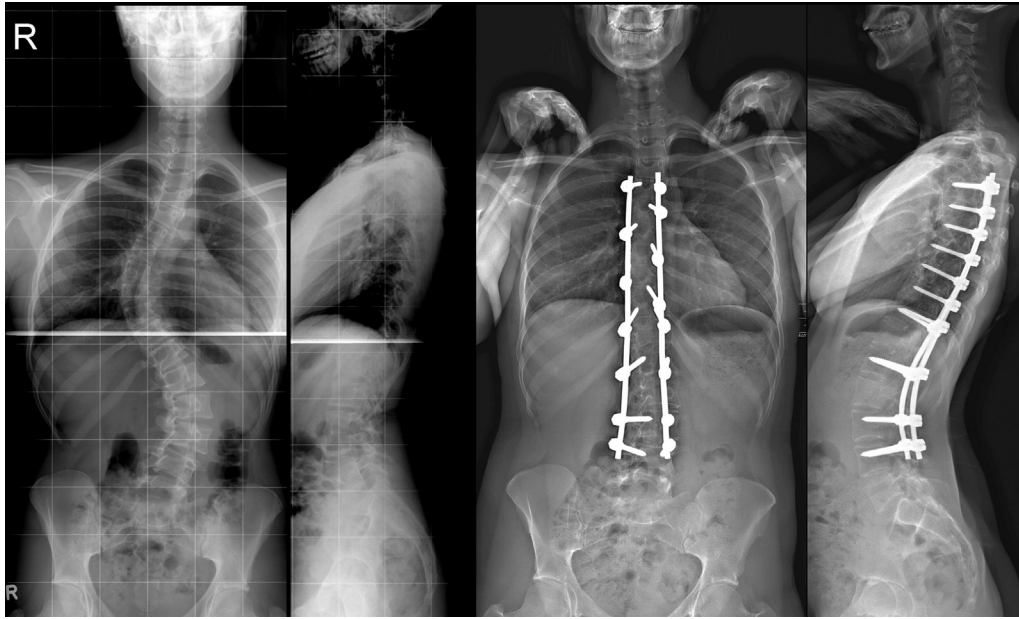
Pre- and postoperative radiographs in posterior instrumentation with correction from 60° Cobb angle to 12° in lower curve and 60° to 10° in upper curve 5 years postoperative.
